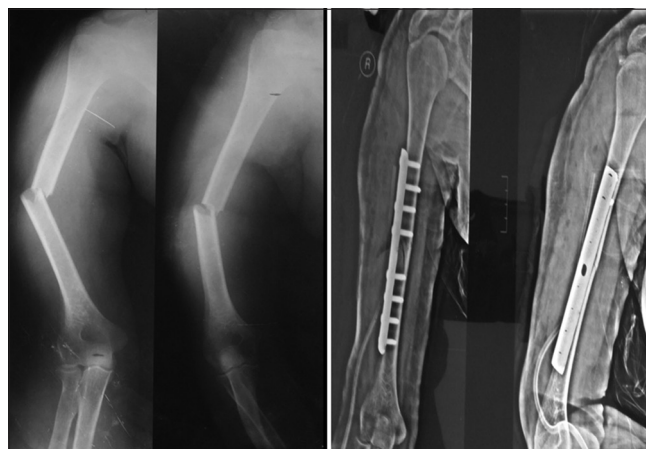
(a) Case 2 - Pre-operative X-ray. (b) Immediate pre-operative X-ray
